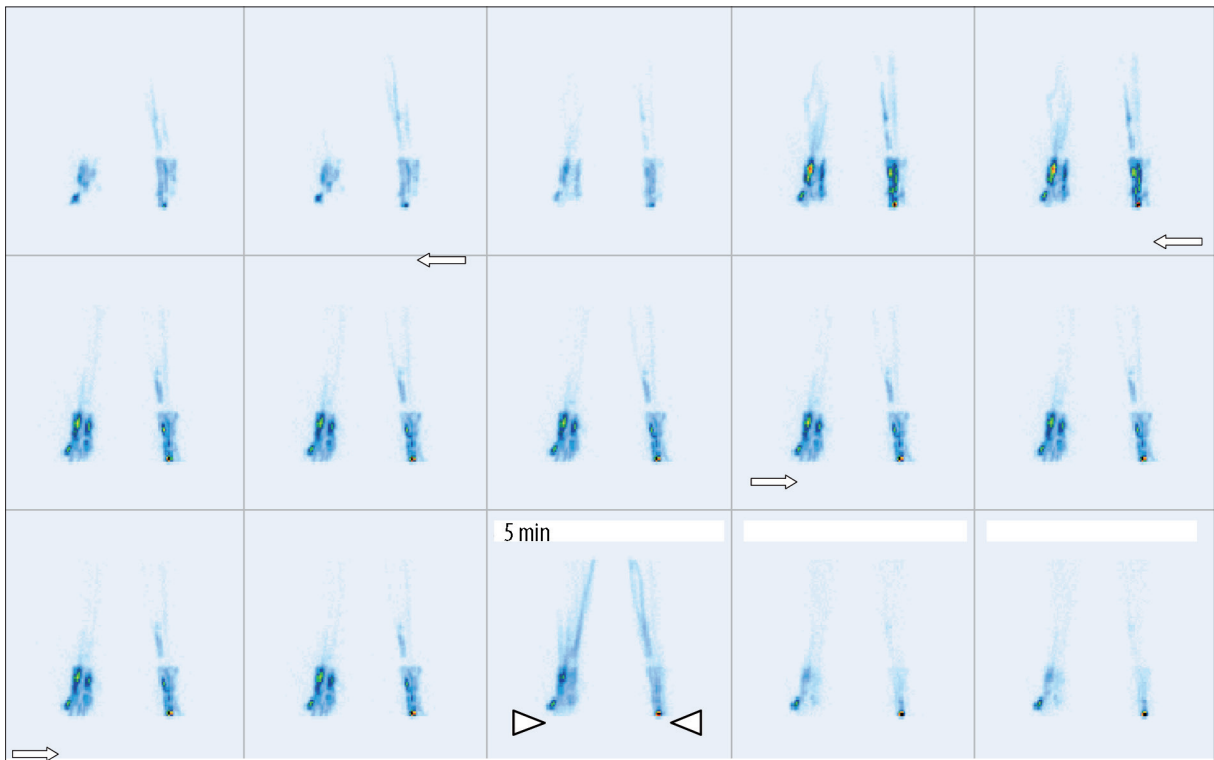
Phleboscintigraphy. Proper radiotracer outflow from the feet was observed via the deep venous system and, after tourniquet release in the 5th minute of examination (arrowheads), also via the superficial venous system. Enlargement of pedal vessels may be observed (arrows).
